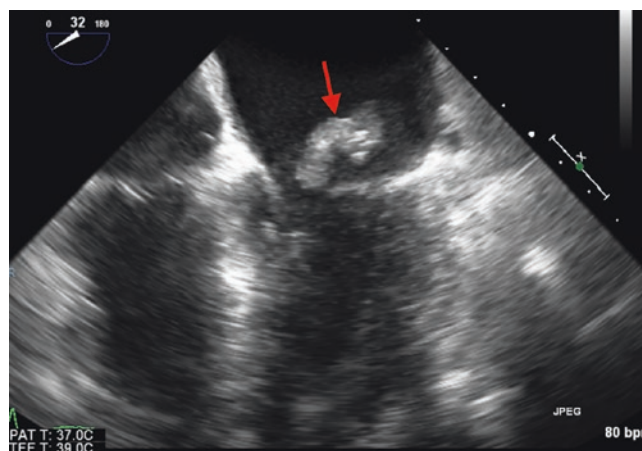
Transesophageal echocardiogram demonstrating a large vegetation (arrow) on the mitral valve in a patient with infective endocarditis. From Shah T: Endocarditis. In Levine G (ed.): Color Atlas of Cardiovascular Disease. 2015, Jaypee Brothers Medical Publishers, Philadelphia, with permission
